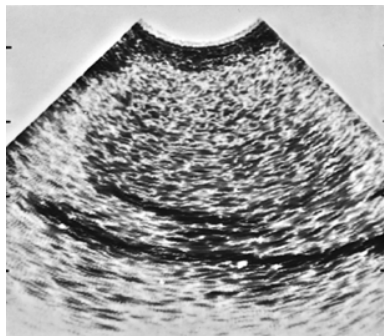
Longitudinal cut of an ultrasonogram of a normal testis. Note the relative uniformity of the body of the testis.
